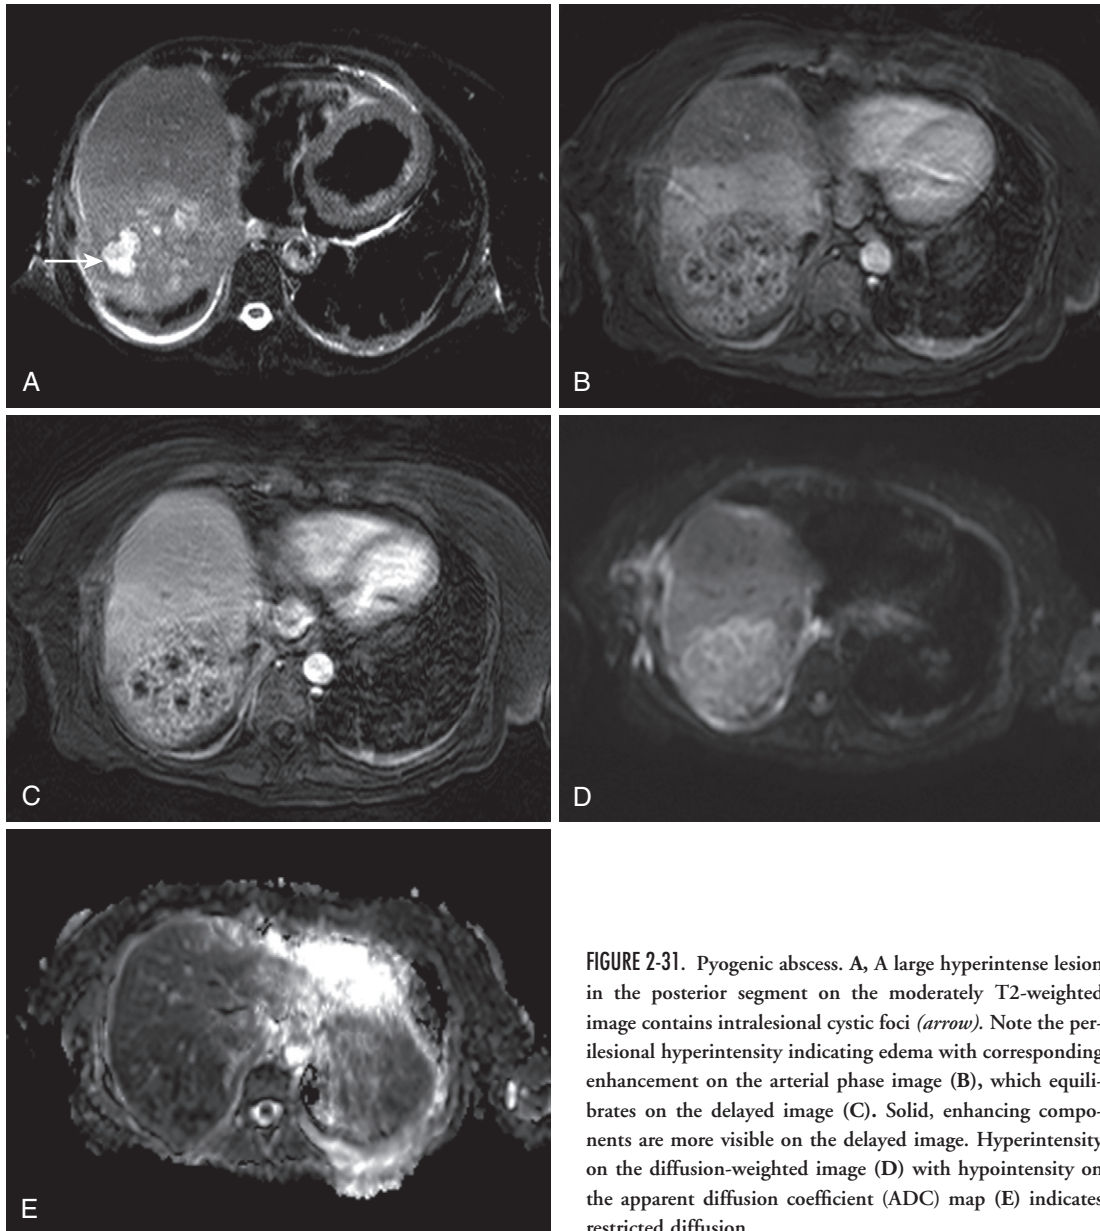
Pyogenic abscess. A, A large hyperintense lesion in the posterior segment on the moderately T2-weighted image contains intralesional cystic foci (*arrow*). Note the perilesional hyperintensity indicating edema with corresponding enhancement on the arterial phase image (B), which equilibrates on the delayed image (C). Solid, enhancing components are more visible on the delayed image. Hyperintensity on the diffusion-weighted image (D) with hypointensity on the apparent diffusion coefficient (ADC) map (E) indicates restricted diffusion.
